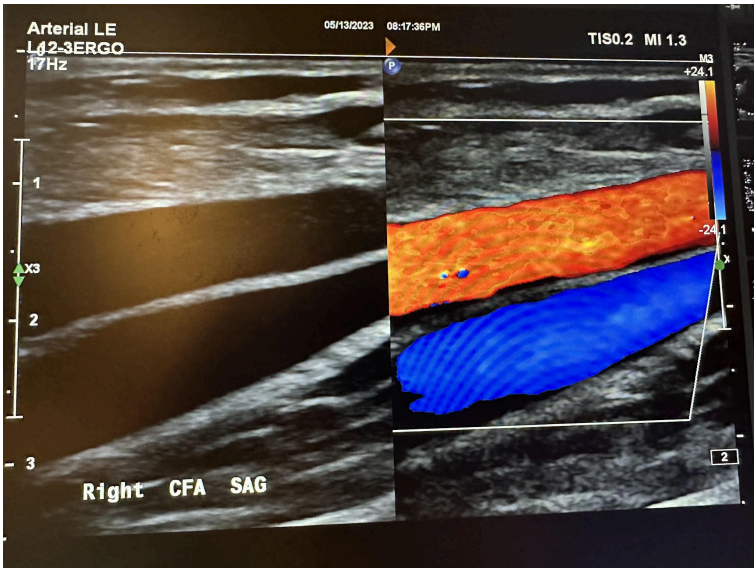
Side-by-side sagittal images of the right common femoral artery without color Doppler and with color Doppler.
